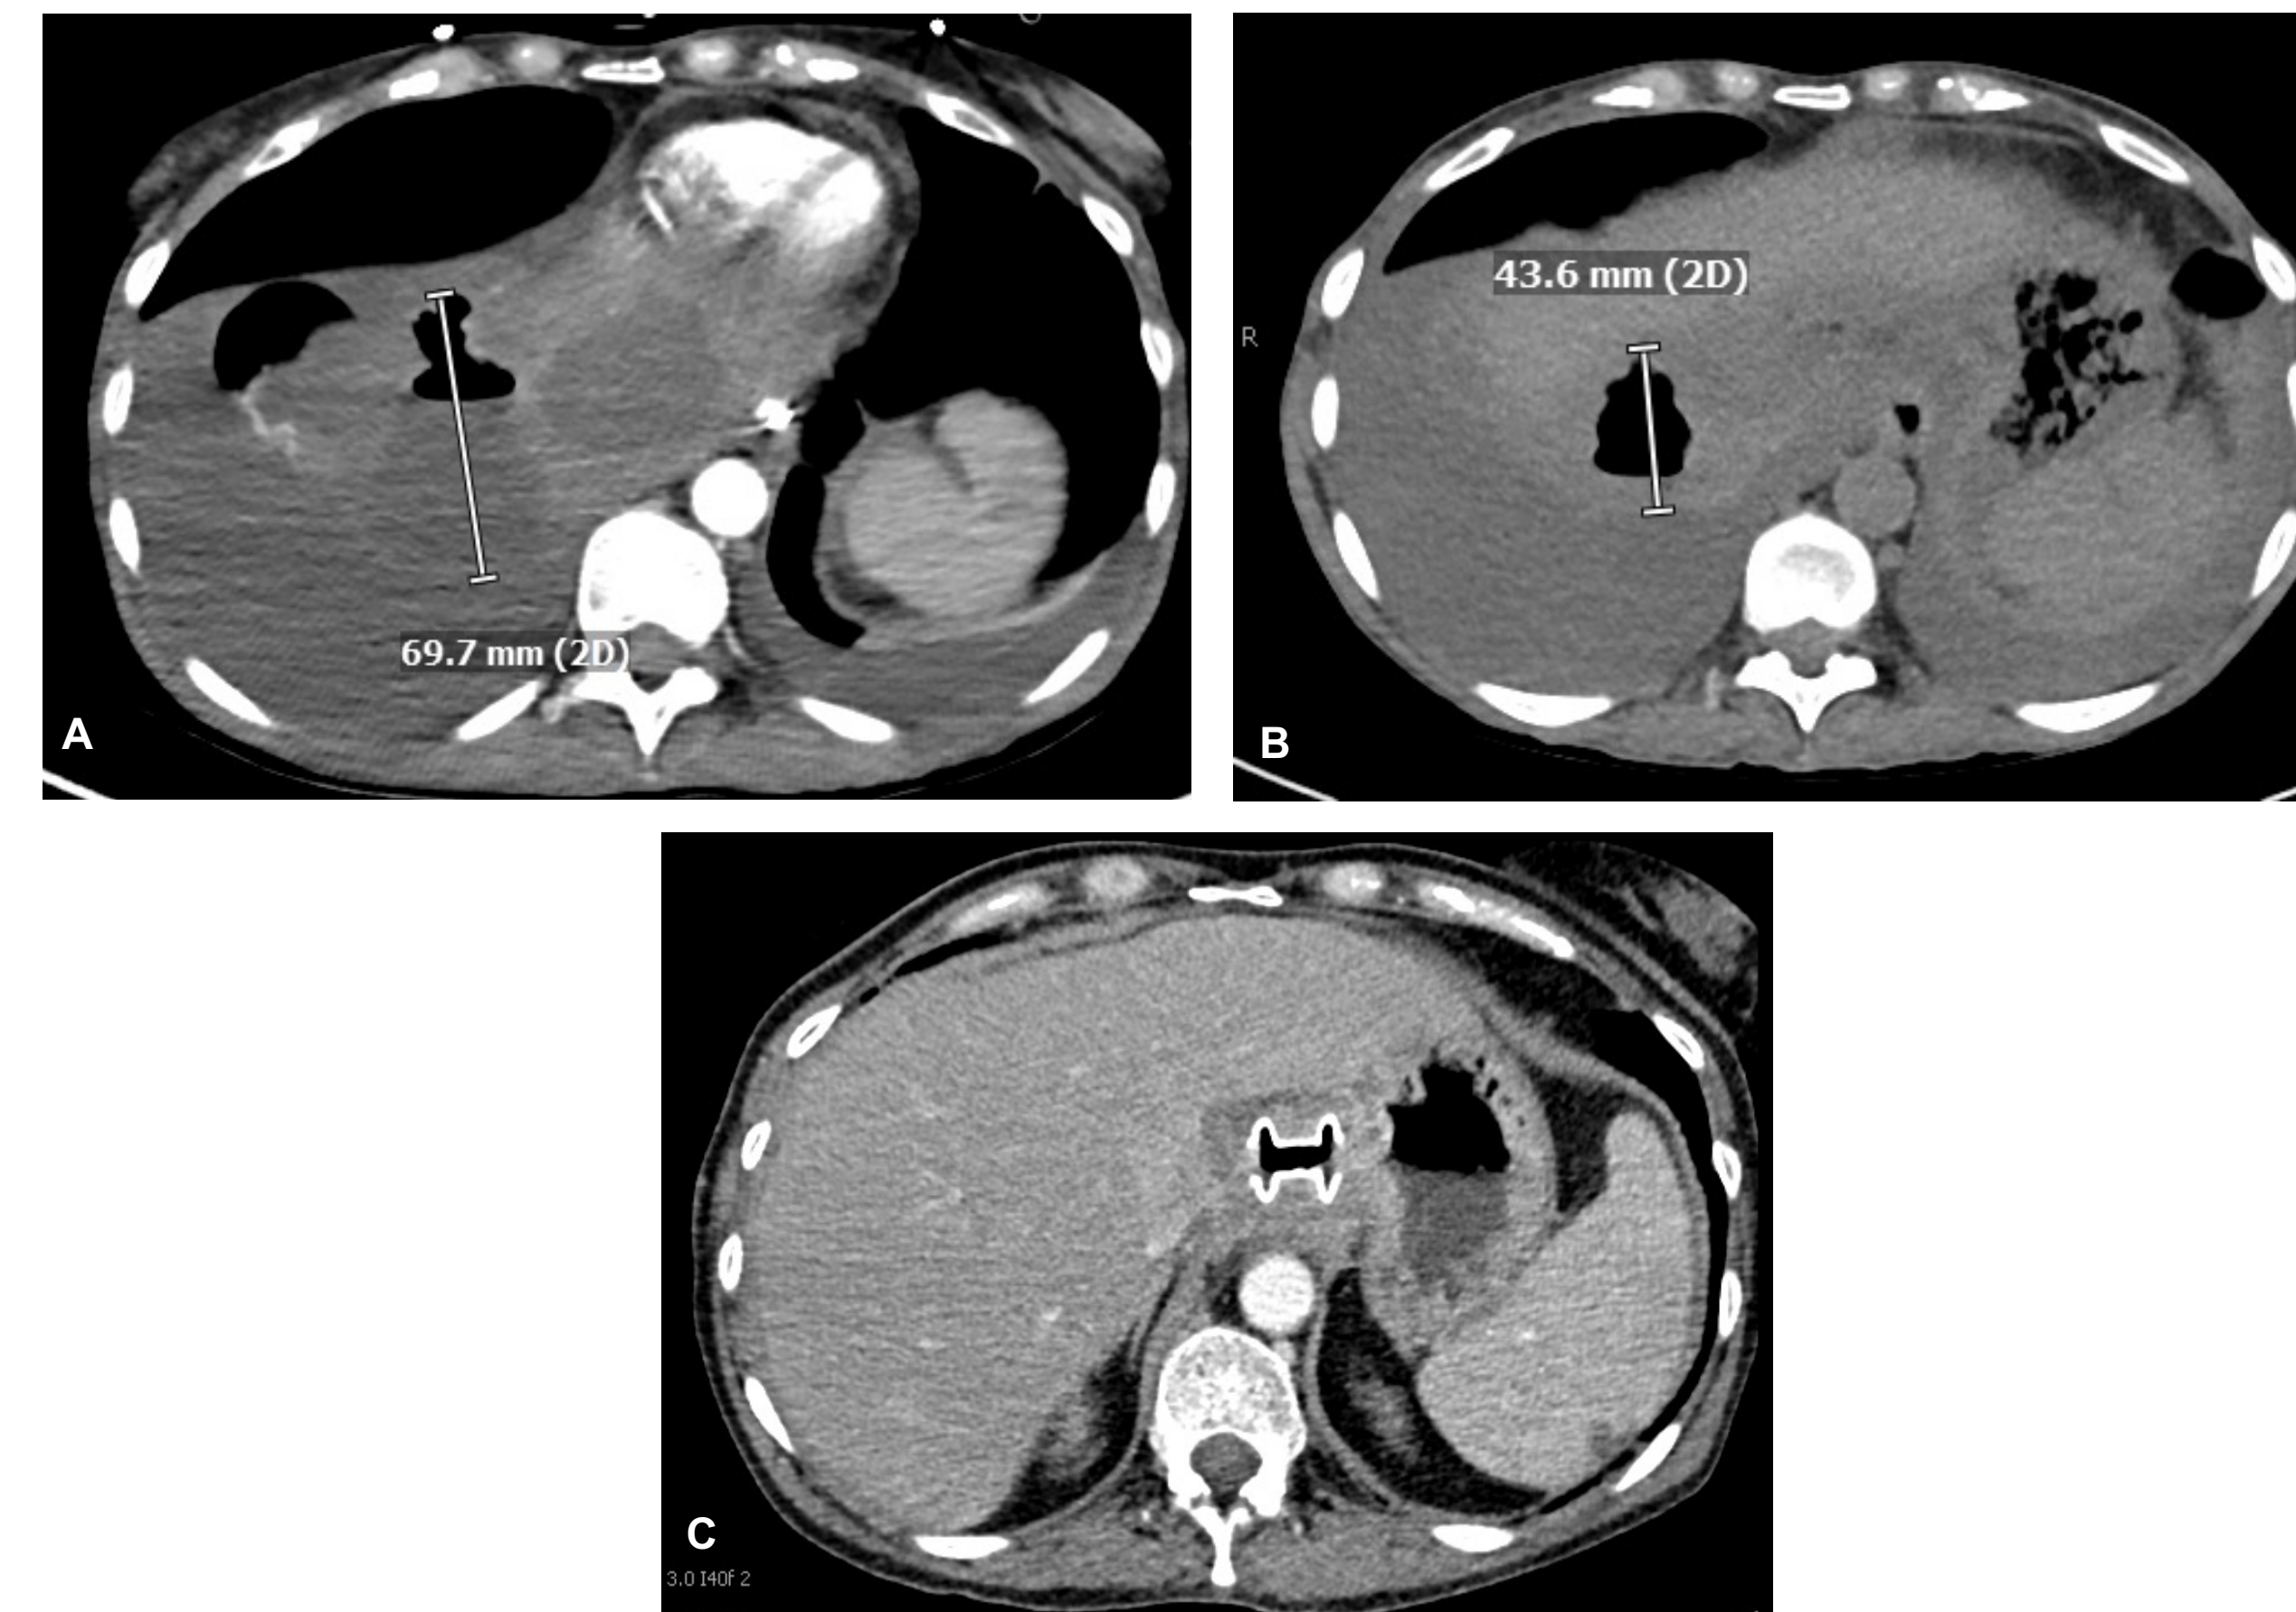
A. CT scan demonstrating a pseudocyst extending through the esophageal hiatus into the mediastinum and right lower lung. B. CT scan showing the stent extending from the proximal stomach to the pseudocyst, which had decreased in size. C. CT scan demonstrating interval resolution of the pseudocyst.
